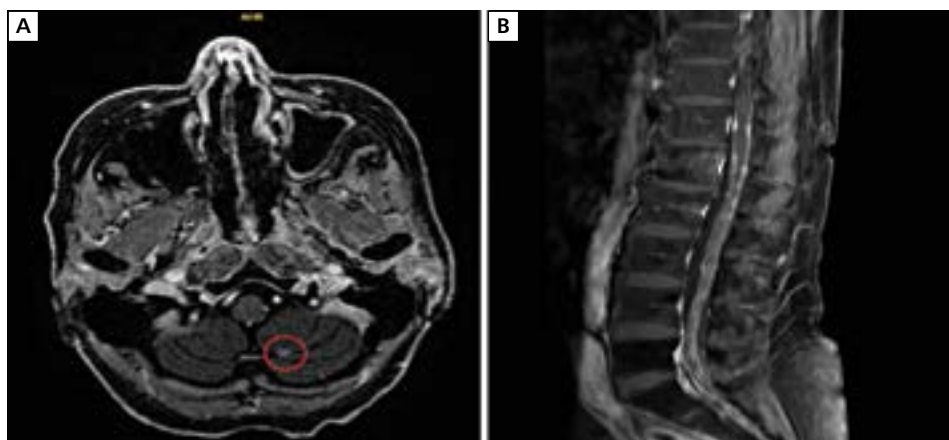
Cranial (A) and spinal (B) leptomeningeal metastases on magnetic resonance imaging; A. Cortical-meningeal metastasis in the left cerebellar region (red circle); B. Extensive spinal leptomeningeal metastasis in the lumbar and sacral regions
